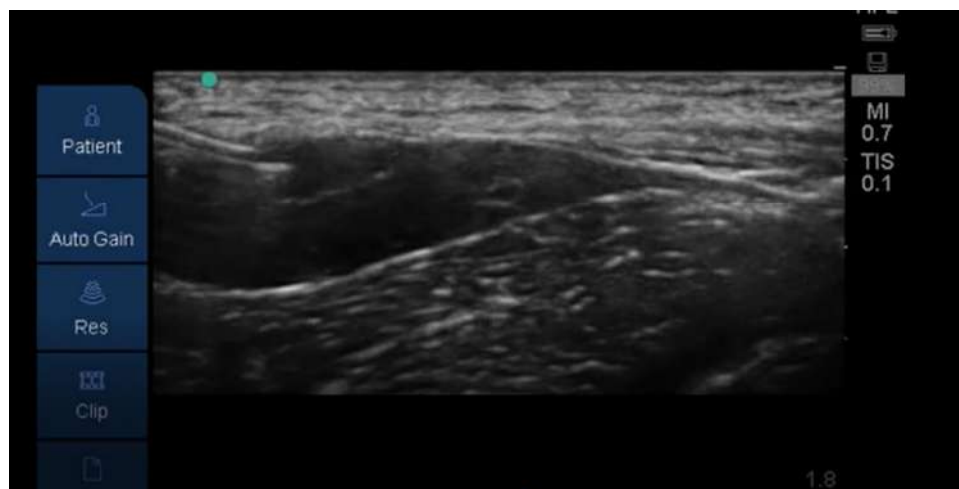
Ultrasound image demonstrating spreading anechoic shadow- drug deposition in FICB
